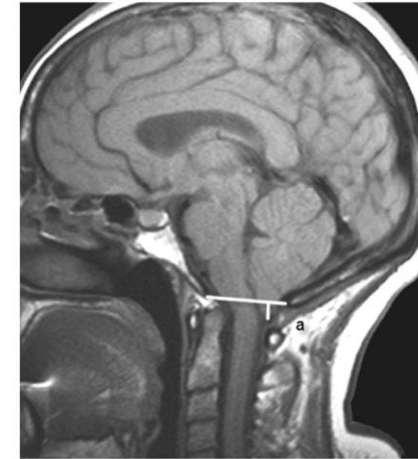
Sagittal Midline T1-weighted MRI of a patient with Chiari type 1 malformation and a tonsillar descent of 5 mm below the foramen magnum (a).
